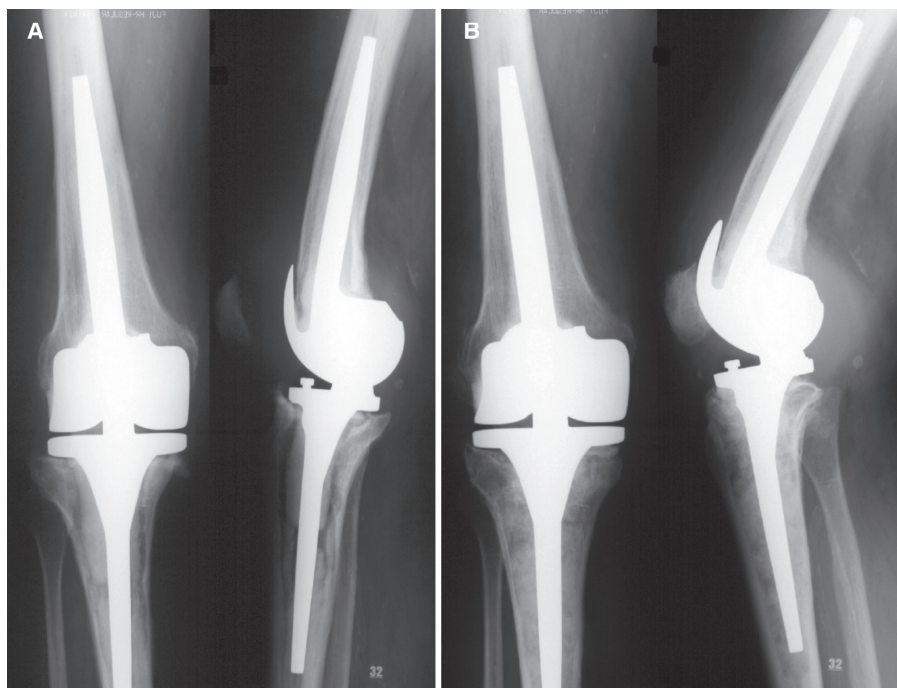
Patient no. 17. Clear radiographic graft incorporation at 9 years following exchange of the tibial component and IBG. A. Preoperatively. B. At follow-up.
